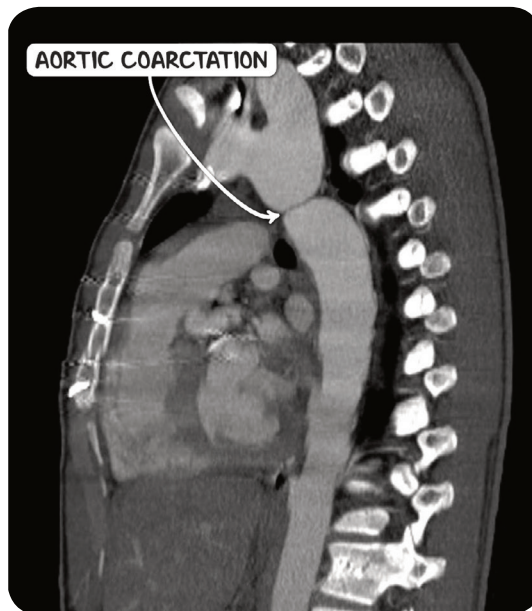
CT scan in the sagittal plane demonstrating coarctation of the aorta.
